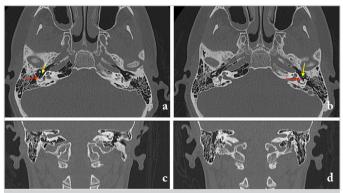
Case B: Right (a-c) and left (b-d) axial and coronal CT scans of the temporal bone showing the bilateral agenesis of the stapes (yellow arrow), the absence of the oval window, and the abnormal position of the facial nerve (red arrow); other ear structures appear normal
